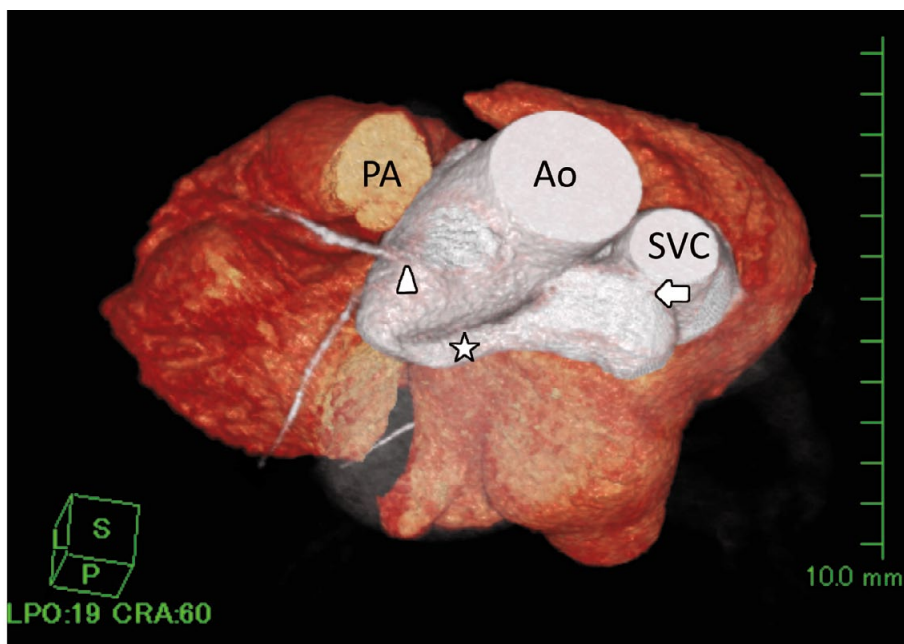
Three-dimensional reconstructed computed tomography of the close relationship between the tunnel and the left main trunk (arrowhead) in the left aortic sinus; the tunnel's retroaortic course; and its termination (arrow). Star, tunnel; Ao, aorta; PA, pulmonary artery; SVC, superior vena cava.
